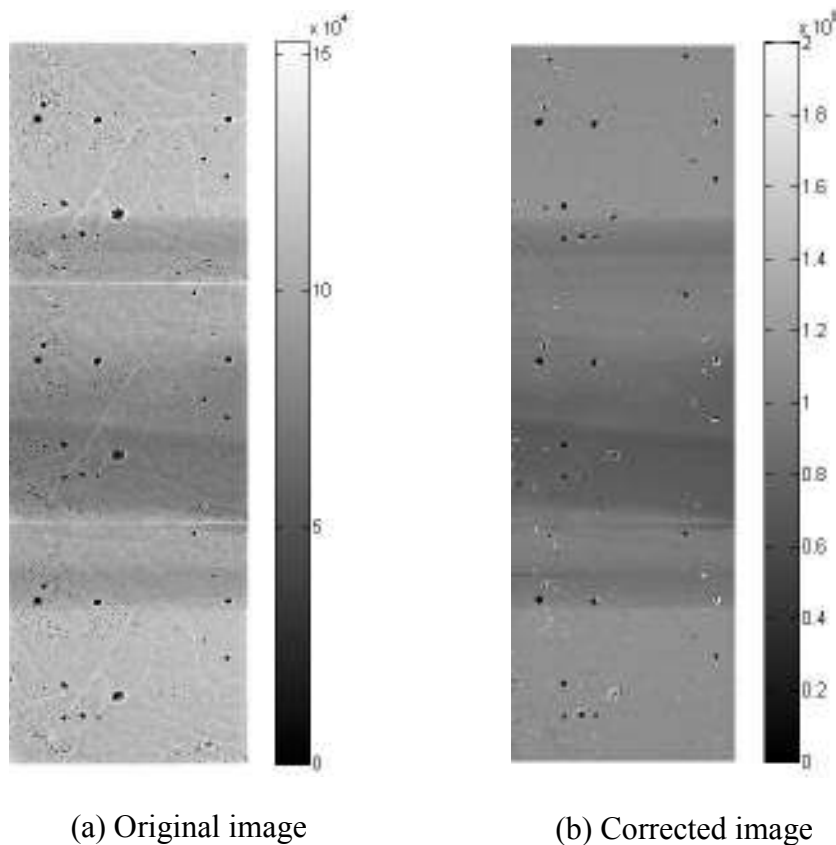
Images of a fat and liver sample obtained (a) before correction for detector response and (b) after applying correction for detector response of individual pixels and x-ray beam profile.
